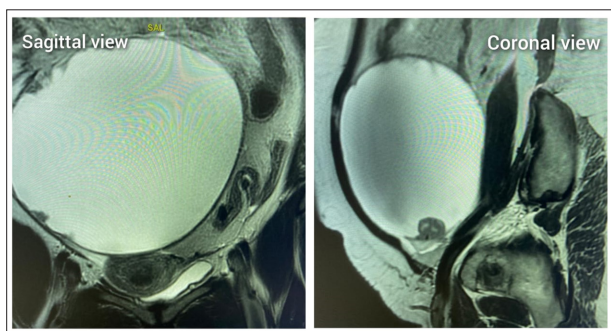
MRI Image (Sagittal and Coronal view) showing large thin walled unilocular anechoic cystic lesion with multiple internal echoes
